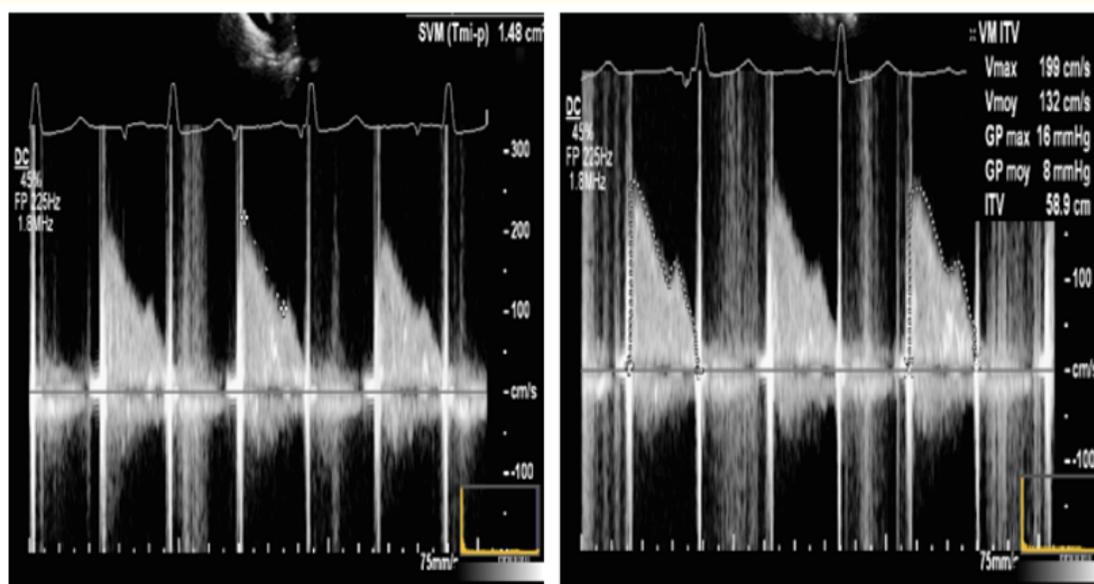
Spectral Doppler envelope of mitral valve inflow shows calculated pressure half-time mitral valve area (MVA) of 1,48 cm² consistent with severe MS, peak pressure gradient (PPG) was 16 mmHg and mean pressure gradient (MPG) was 8 mmHg.
